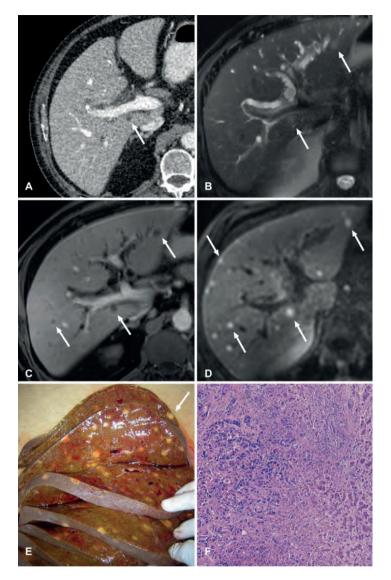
A 64-year-old male patient with borderline resectable pancreatic cancer on CECT and indeterminate liver lesions. The lesions were characterized as liver metastases by Gdenhanced MRI. DWI additionally showed > 100 metastases. The time interval between CT and MRI was 11 days. In this patient, there was a large discrepancy between CECT and Gd-enhanced MRI and DWI. Within 4 weeks after initial diagnosis, the patient died of cholangitis septicemia. An autopsy was performed and confirmed MRI findings of more than 100 liver metastases. CECT (a) shows multiple hypodense liver lesions too small to characterize. These lesions show moderately high signal intensity on T2W-HASTE (b), and post-contrast T1W-VIBE portal-venous phase (c) shows rim enhancement. Diffusion-weighted MRI shows multiple lesions (white arrows) with a high signal intensity that remain hyperintense on the high b-value b = 800 s/mm2 (d). The autopsy confirmed there were more than 100 liver metastases (E&F).
